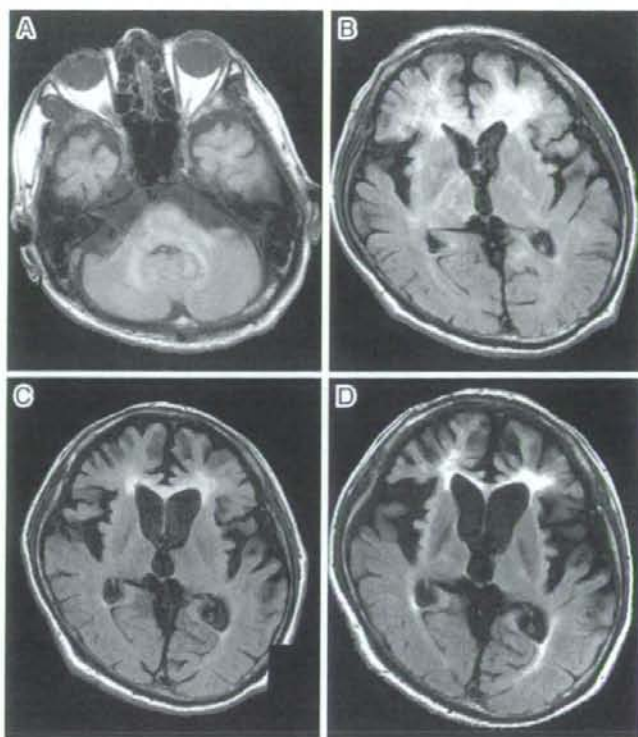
Brain MRI (FLAIR) of case 1
